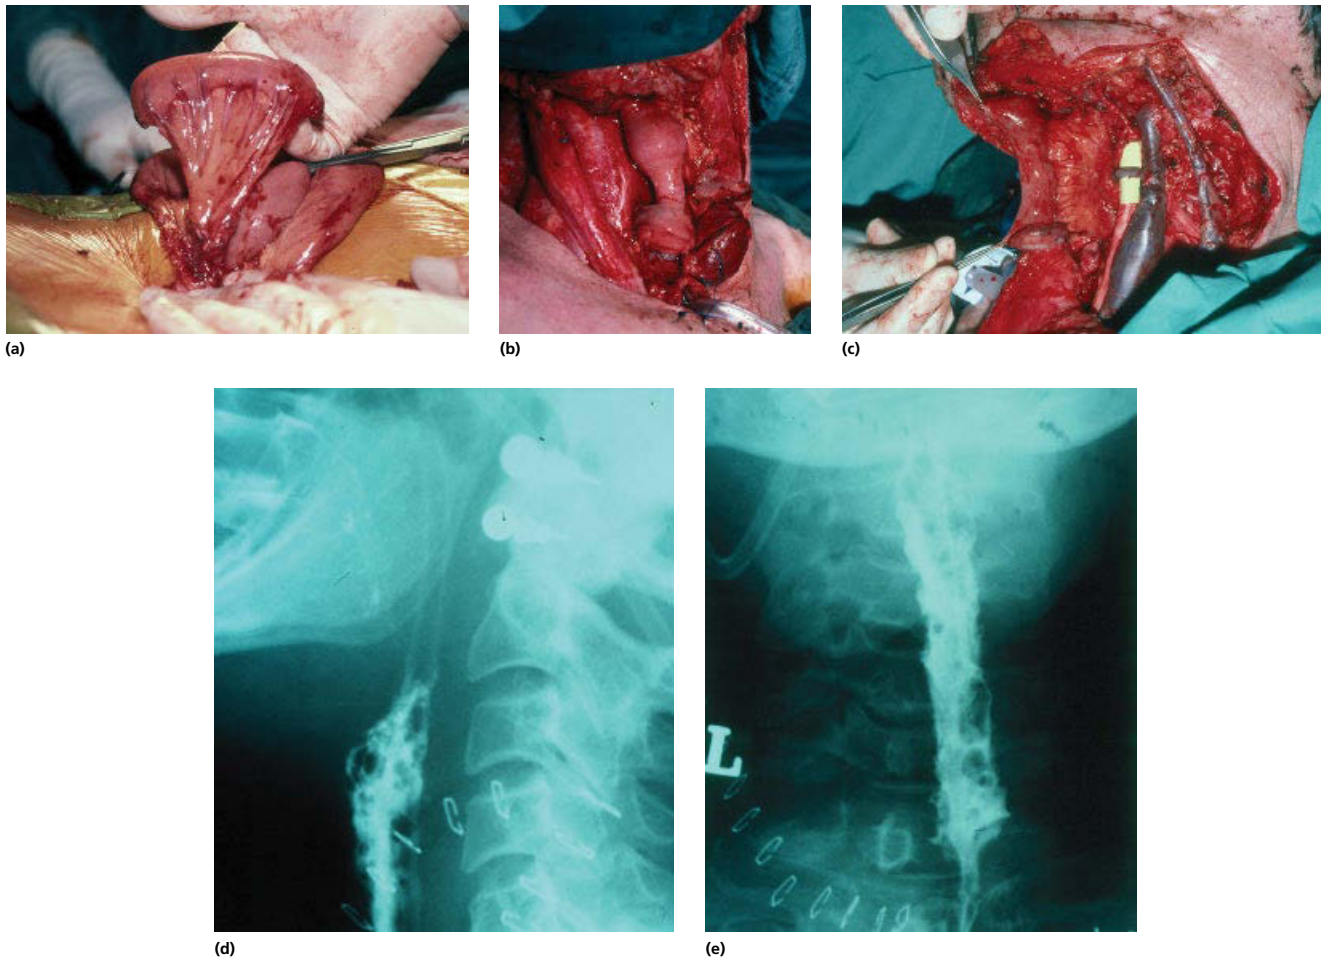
(a, b, c, d, e) Jejunum harvest and inset with follow-up contrast swallow X-rays.
